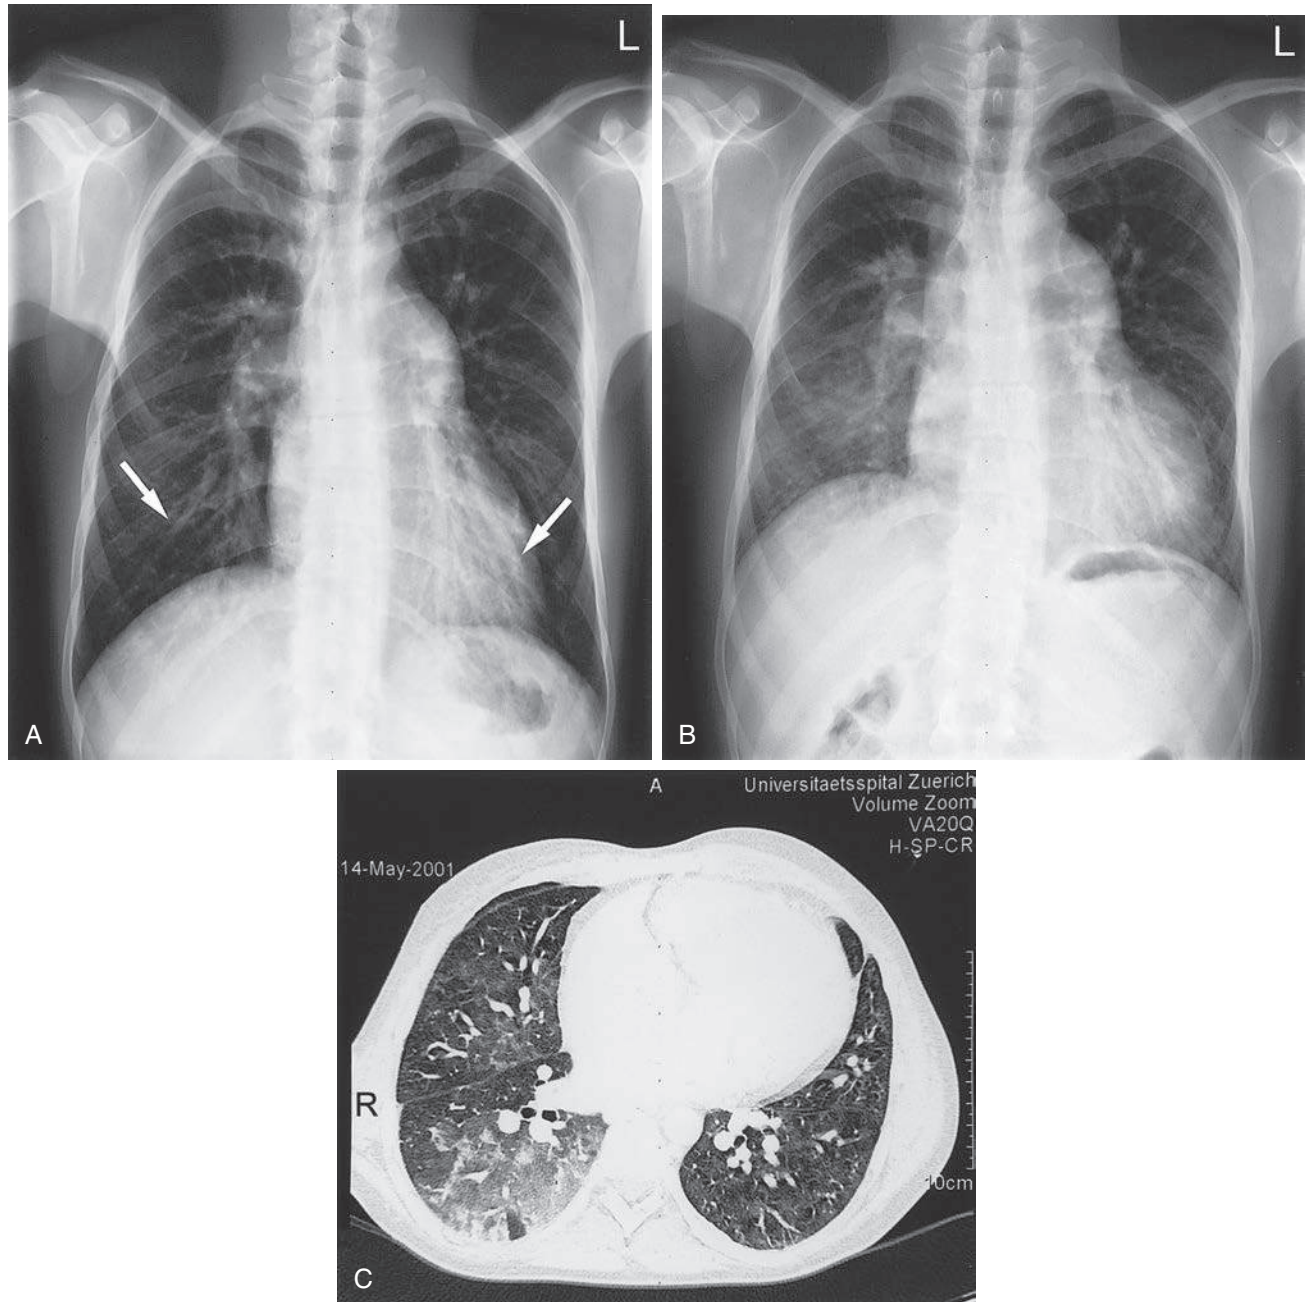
Intrapulmonary hemorrhage in a 29-year-old man with atrioventricular concordance and ventriculoarterial discordance (d-transposition of the great arteries), nonrestrictive subaortic ventricular septal defect, previous Blalock-Hanlon atrial septectomy, patent ductus arteriosus, and Eisenmenger syndrome. A, Chest radiograph at age 26 years shows dilation of the main pulmonary trunk and the smaller division branches uniformly throughout the lungs (*arrows*). The aortic arch is small. The lungs are clear. B, The patient presented 3 years later with mild hemoptysis. Acinar consolidation is present in the right lower lung and represents intrapulmonary hemorrhage. Cardiothoracic ratio has increased from 0.52 to 0.60. C, Computed tomogram obtained on the same day shows extensive acinar consolidation (intrapulmonary hemorrhage) in the right lower lobe and in the middle lobe. (Courtesy B. Marincek, Institute of Diagnostic Radiology, University Hospital, Zurich, Switzerland.)
